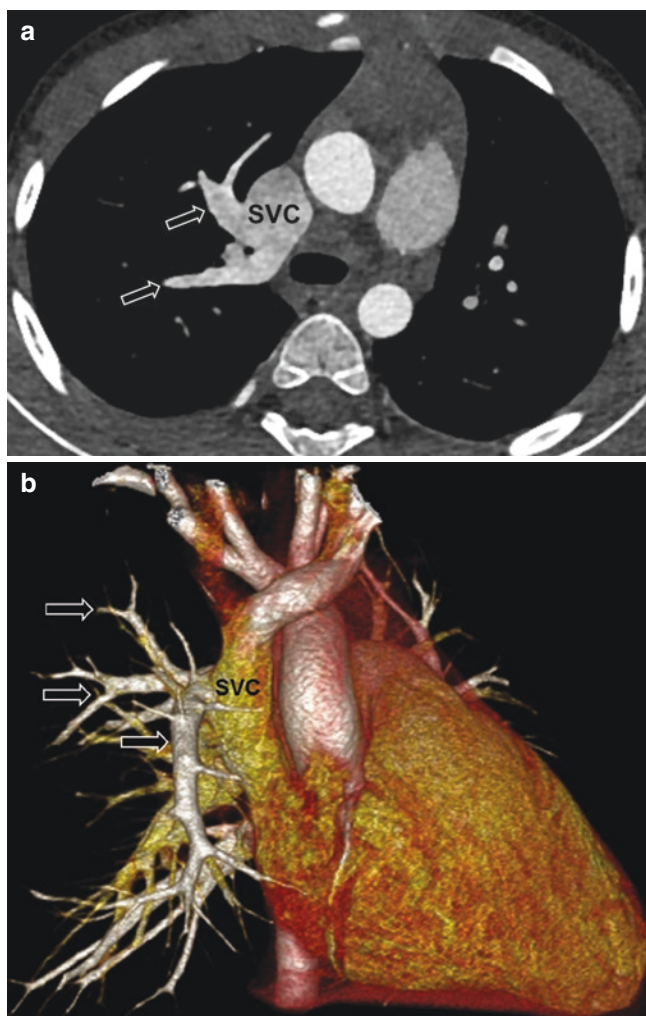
A 5-year-old girl with right upper lobe partial anomalous pulmonary venous return. Axial enhanced CT image (a) and 3D volume-rendered CT image (b) show right upper lobe pulmonary veins (arrows) draining into the superior vena cava (SVC)
